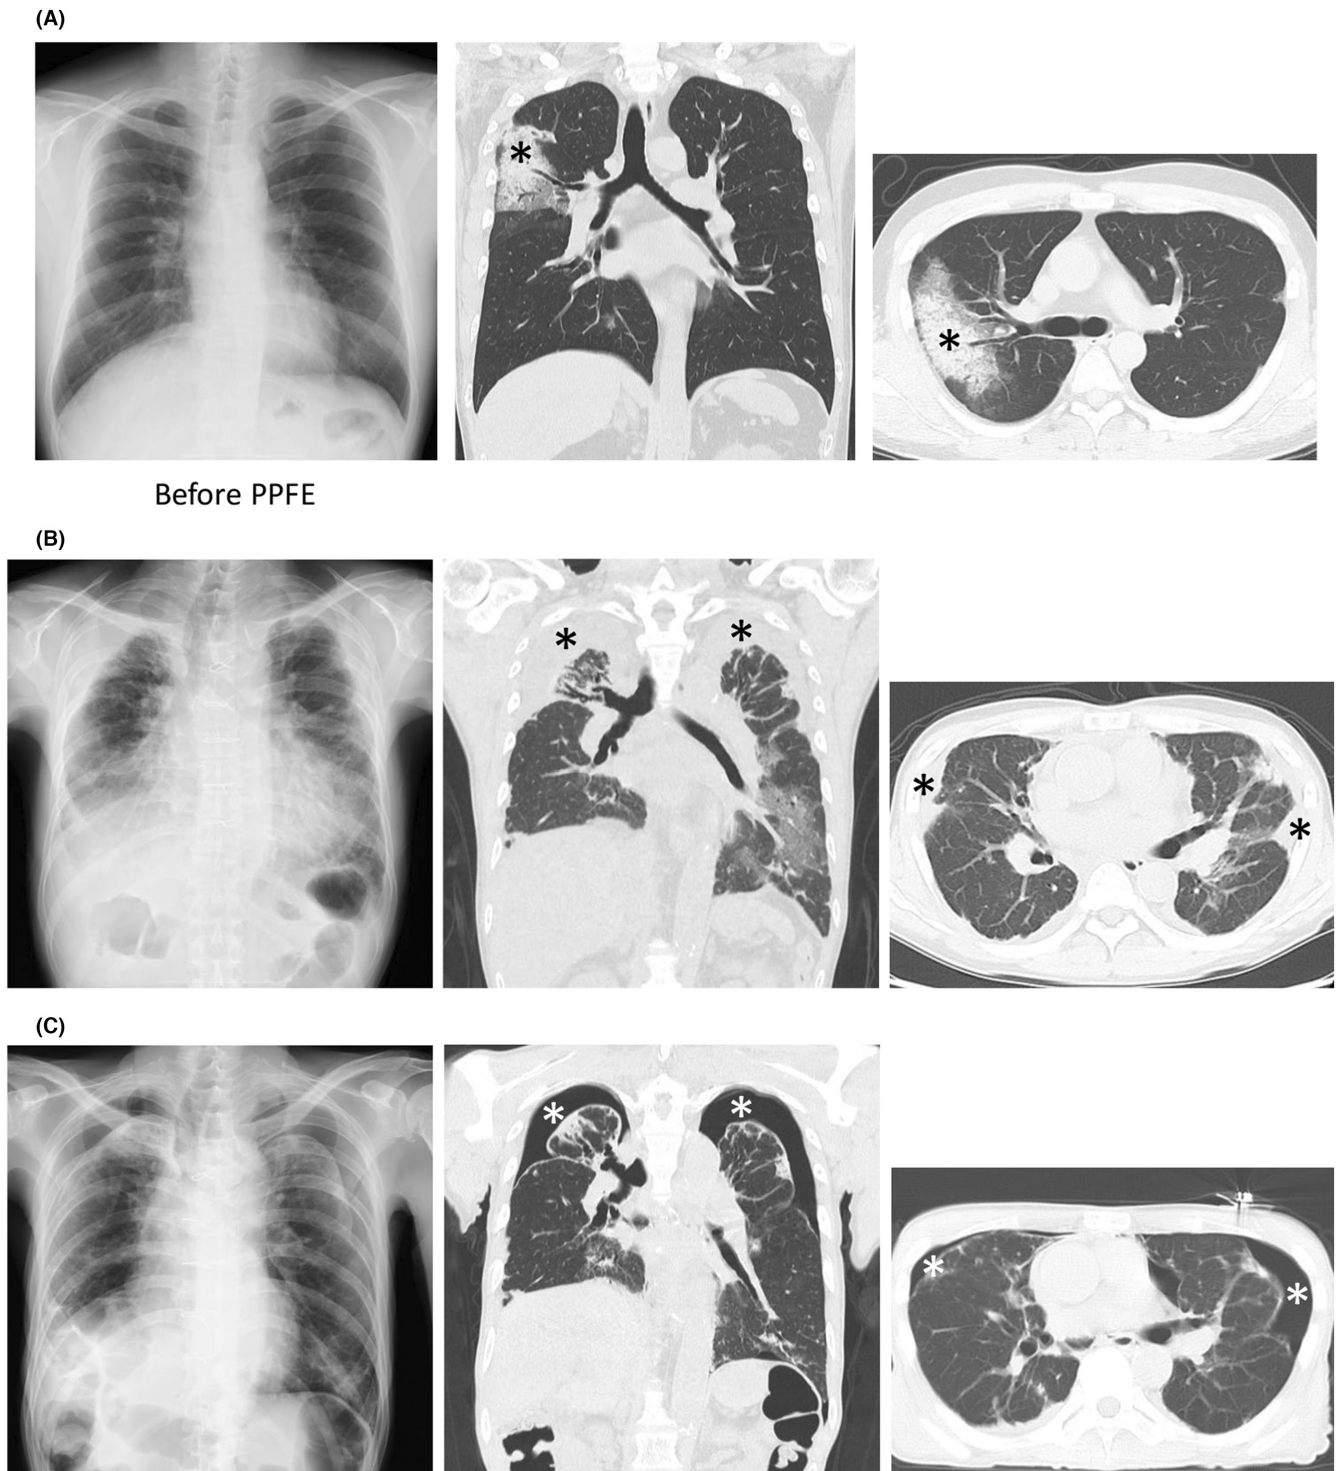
Patient pulmonary imaging. (A) Chest x-ray and CT before pleuroparenchymal fibroelastosis (PPFE). Seven years after hematopoietic stem cell transplantation, the patient's pulmonary lesion onset was a ground glass opacity on his right upper lobe (*indicated with asterisk in the center and right panel), which was not revealed on chest x-ray (left panel). We treated the patient with corticosteroid therapy and the patient responded favorably. (B) Chest x-ray and CT findings of the PPF. The center and right columns represent the CT image of the patient in the coronal and cross-sectional sections, respectively. CT revealed significant bilateral apical pleural thickening and severe volume reduction of the bilateral apex (*indicated with black asterisk in the center and right panel). It was also discovered that architectural distortion caused traction bronchiectasis and peripheral consolidation. (C) Chest x-ray and CT findings of PPF after the treatment of pulmonary congestion. The center and right columns represent the CT image of the patient in the coronal and cross-sectional sections, respectively. The patient had complicated pulmonary cardiac failure with massive pleural effusion around the bilateral pleura (left top and bottom panels). Following modest treatment of congestion, pneumothoraces became clear in the bilateral lung (*indicated with white asterisk in the center and right panel).
